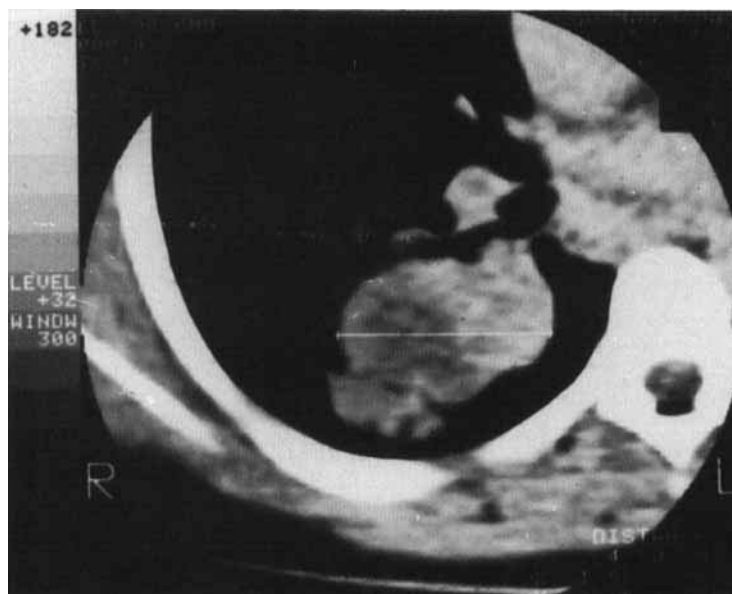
CT scanning shows the tumor in the right hemithorax at the moment of diagnostic. Transverse diameter 9 cm.
